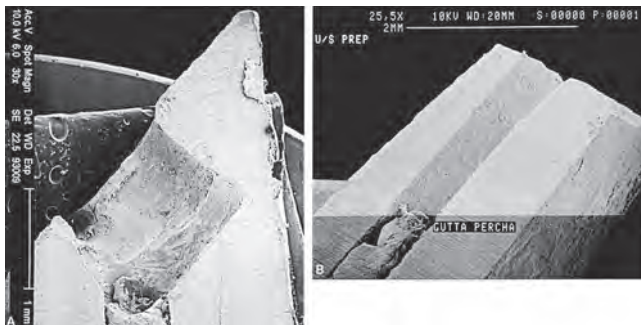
Comparison between a bur and ultrasonic root-end preparations. Left, Bur preparation shows a large cavity prepared oblique to the canal with a no. 33 inverted cone bur ($\times 30$ original magnification). Right, Ultrasonic preparation shows a clean preparation parallel to the canal ($\times 25.5$ original magnification). Courtesy of G. Wuchenich and D. Meadows.
